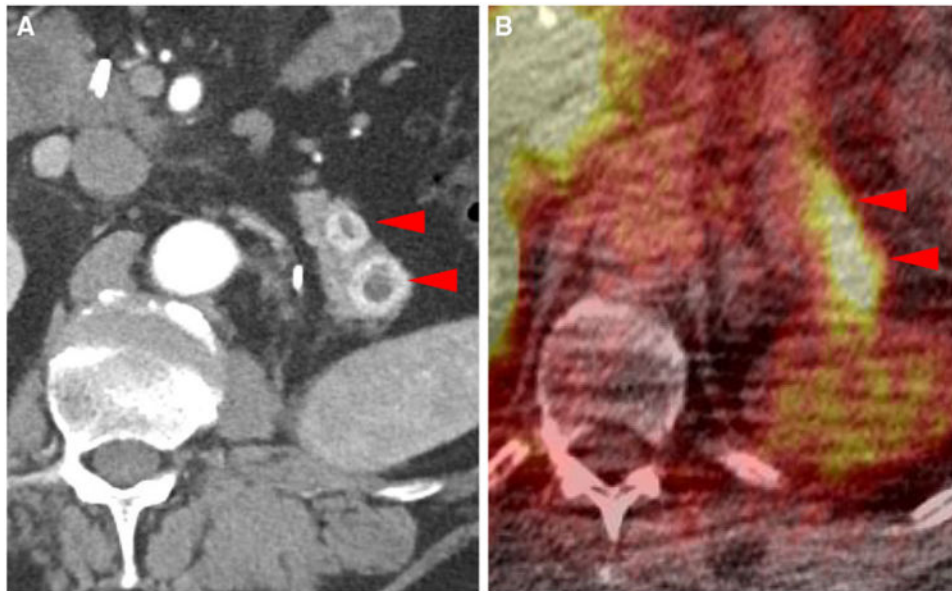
Metastatic lesions to the pancreatic tail in patient #1 (SUV_{max} 5.0 in the more anterior lesion and SUV_{max} 7.4 in the more posterior lesion) as noted on contrast-enhanced CT (a) and ^{18}F -DCFPyL PET/CT (b) (*arrowheads*)
